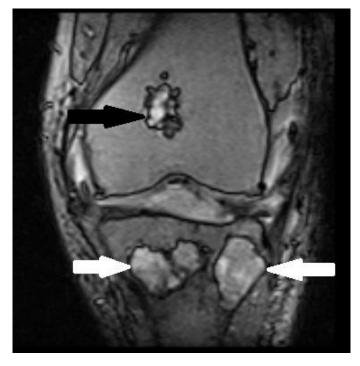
56 year-old man with Enchondromatosis. Image acquired on a G-Scan 0,25 Tesla MR scanner. GE-T1-weighted (TR: 1200 TE: 22 TI: 0 FA: 35) coronal image of left knee which shows multiple enchondromas in the distal femur (black arrow) and proximal tibia (white arrows).
